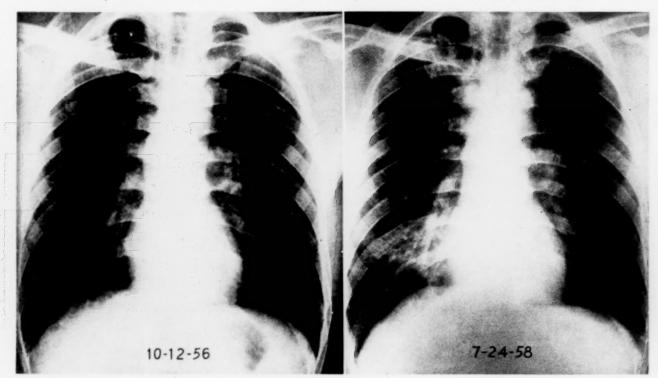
Roentgenograms of patient E. C. obtained two years prior to hospital admission, and at time of admission. They showed progression of small nodular lesion in right apex to cavitation and spread to the middle lobe of the right lung prior to onset of treatment.
